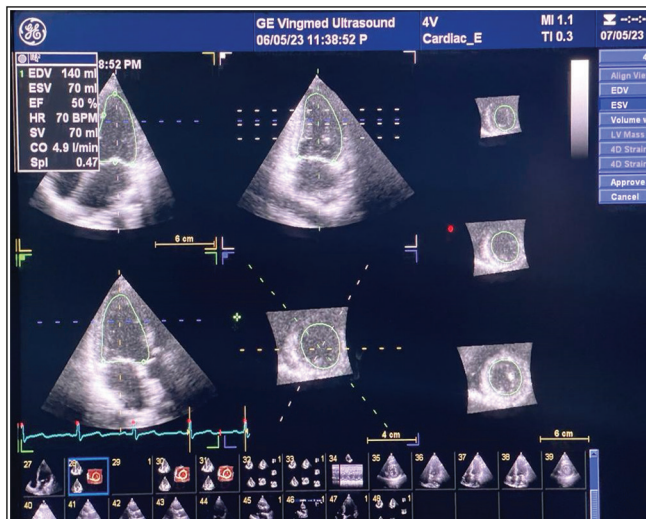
Measurement of ejection fraction and sphericity index by 3D echocardiography
